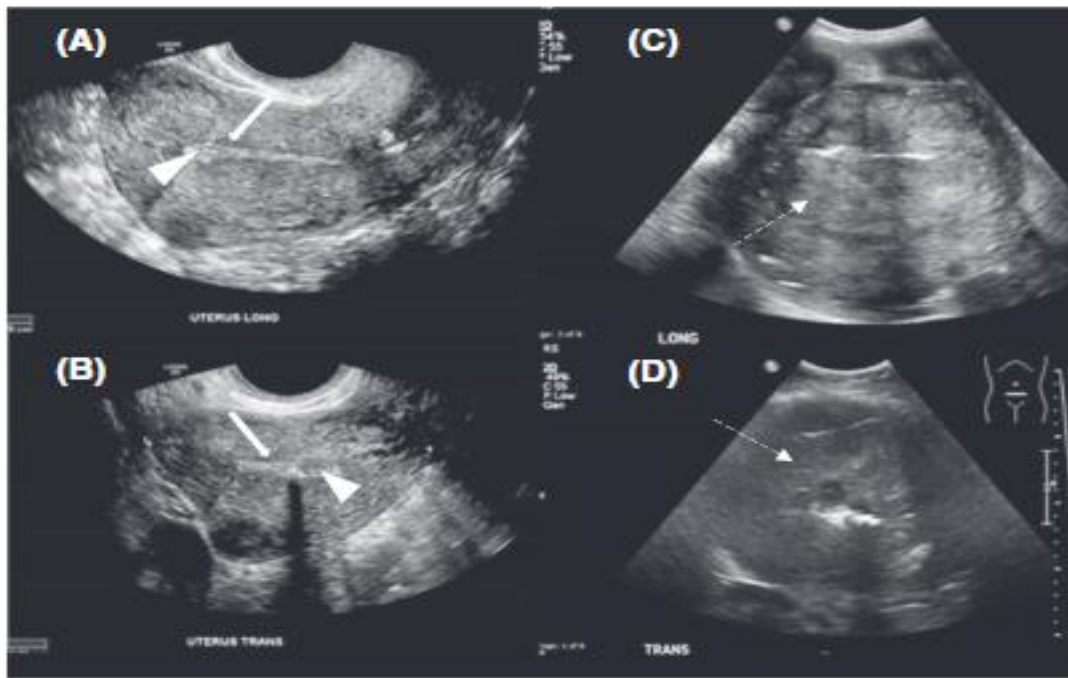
Ultrasound scans of a normal uterus. Transvaginal ultrasound scans of (A) sagittal plane (long) and (B) axial plane (Trans) with normal, thin, uniform echogenic endometrium (arrowheads) and sub-endometrial hypoechoic halo (solid arrows). Transabdominal ultrasound scans of endometrial carcinoma in sagittal plane (C) and axial plane (D). Note the cause of heterogeneous echogenicity due to haemorrhage and, necrosis.^[10]
